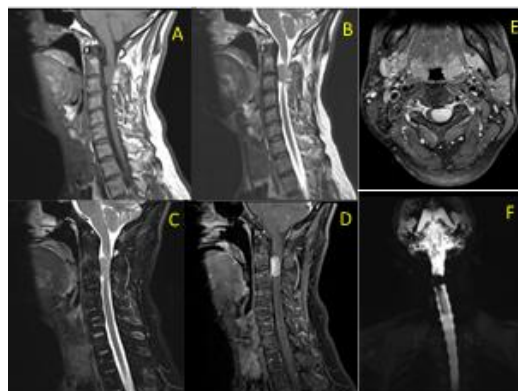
MRI whole spine sagittal and axial showing a solid mass intradural extramedullary at the C2-C3 level with perifocal edema. (A) The mass
